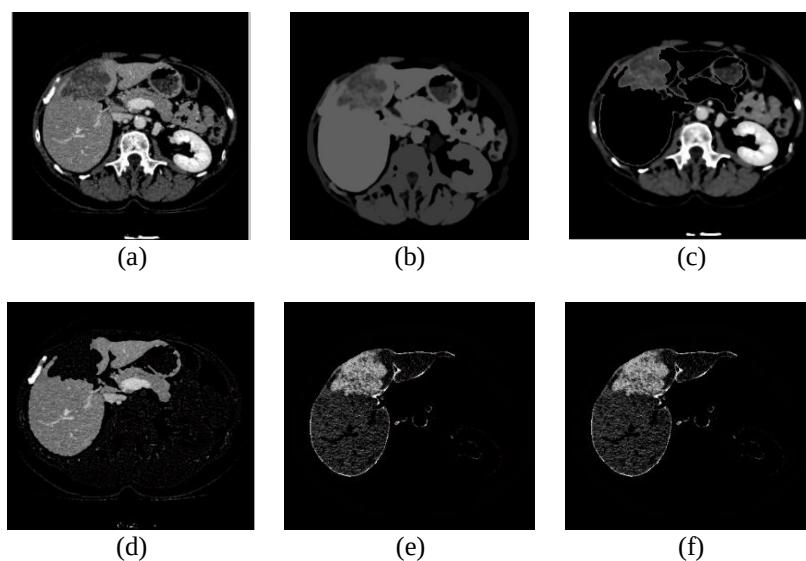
Training and testing images of (a) original abdominal CT images, (b) shape sharpening image, (c) liver segmented without tumor region, (d) liver segmented image, (e) tumor identification, and (f) tumor extraction region
